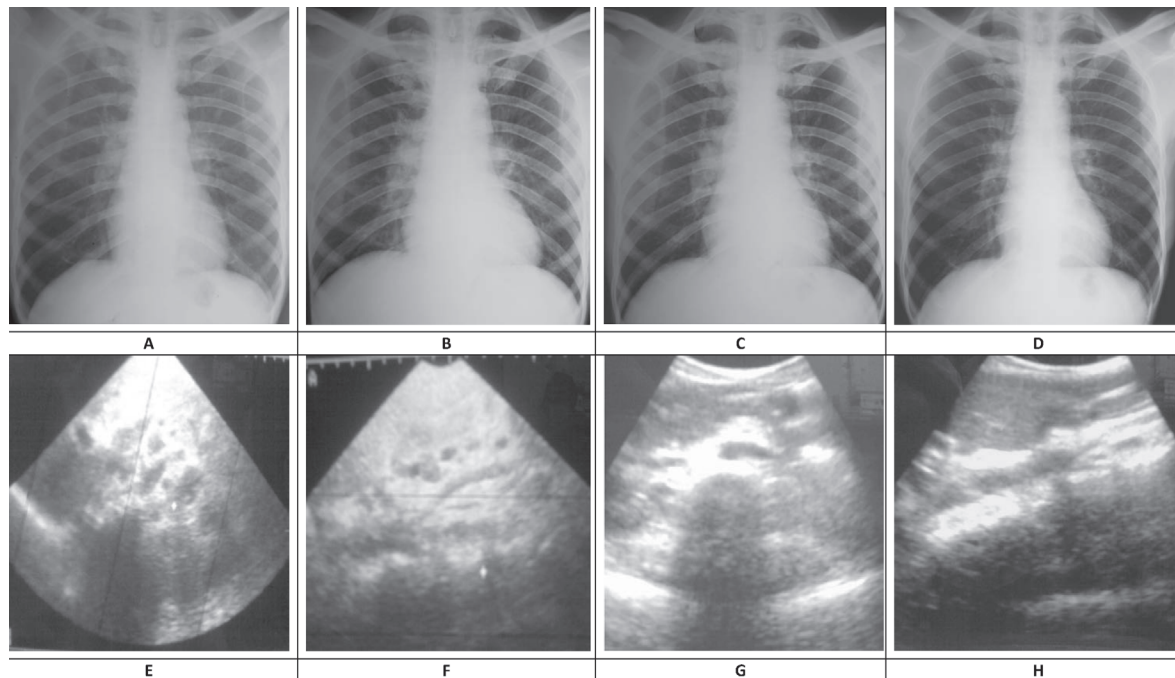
Chest X-ray (A-D) and ultrasonogram abdomen (E-H). A: Before starting antitubercular therapy (ATT); B: Day 3 of immune reconstitution inflammatory syndrome (IRIS) event; C: Day 25 of IRIS event; D: End of ATT; E and F: Day 9 after IRIS event; E: Extensive mesenteric adenitis; F: enlargement of lymph nodes along the portal vein; G and H: End of ATT after steroid therapy showing clearance; G: mesenteric and para-aortic region; H: along the portal vein.
